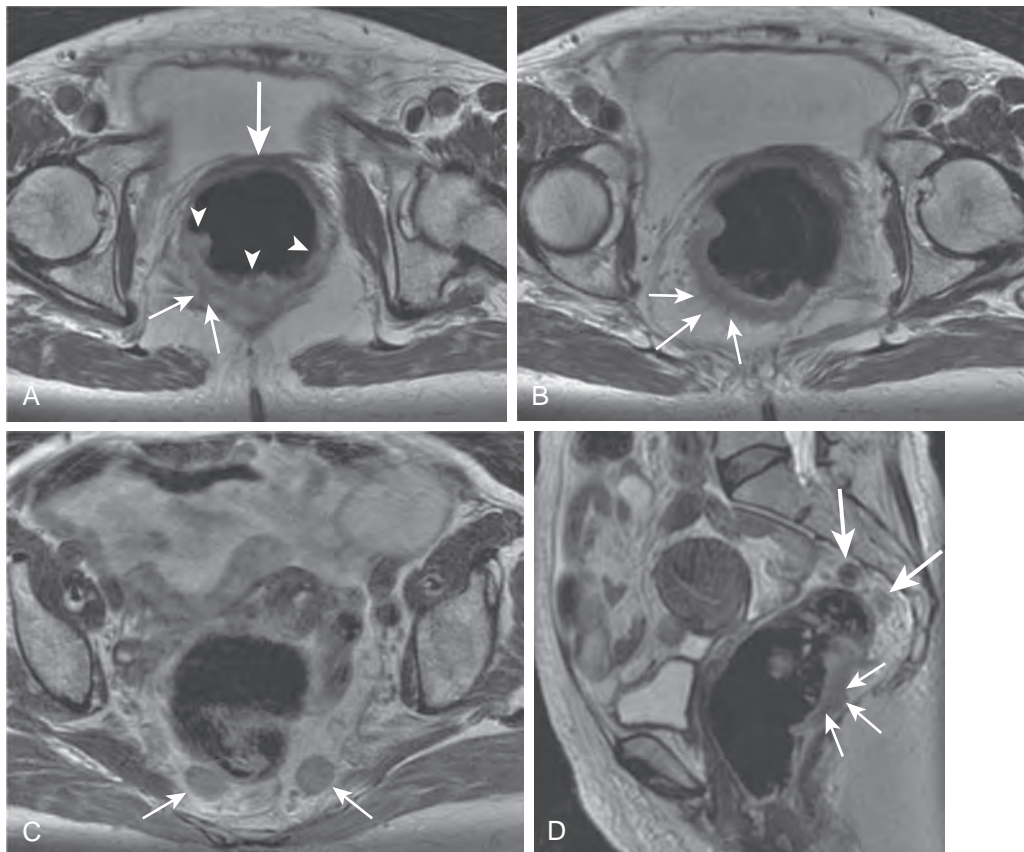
MRI scans of rectal adenocarcinoma with extension beyond the bowel wall (T3N1M0; Dukes' stage C2). A. Axial T2-weighted fast spin-echo image demonstrates a nodular outer margin of the posterolateral rectal wall with broad-based extension of soft tissue (small arrows) into perirectal fat. The luminal margin of the tumor is irregular (arrowheads), and signal intensity of the tumor is higher than that of the muscularis propria (large arrow). B. Axial T2-weighted fast spin-echo image shows spiculated outer margin (arrows) of mass involving posterior and right lateral aspects of the rectum. These features suggest a desmoplastic reaction related to tumor rather than neoplastic infiltration of perirectal fat. C. Axial T2-weighted fast spin-echo scan at higher level than A and B depicts prominent presacral lymph nodes (arrows) indicative of malignant lymphadenopathy slightly remote from primary tumor (N2). D. Sagittal T2-weighted fast spin-echo image confirms enlarged lymph nodes (large arrows) in the presacral space. The nodular outer margin of the rectal mass (thin arrows) is well demonstrated on sagittal view, suggesting invasive tumor (T3).
